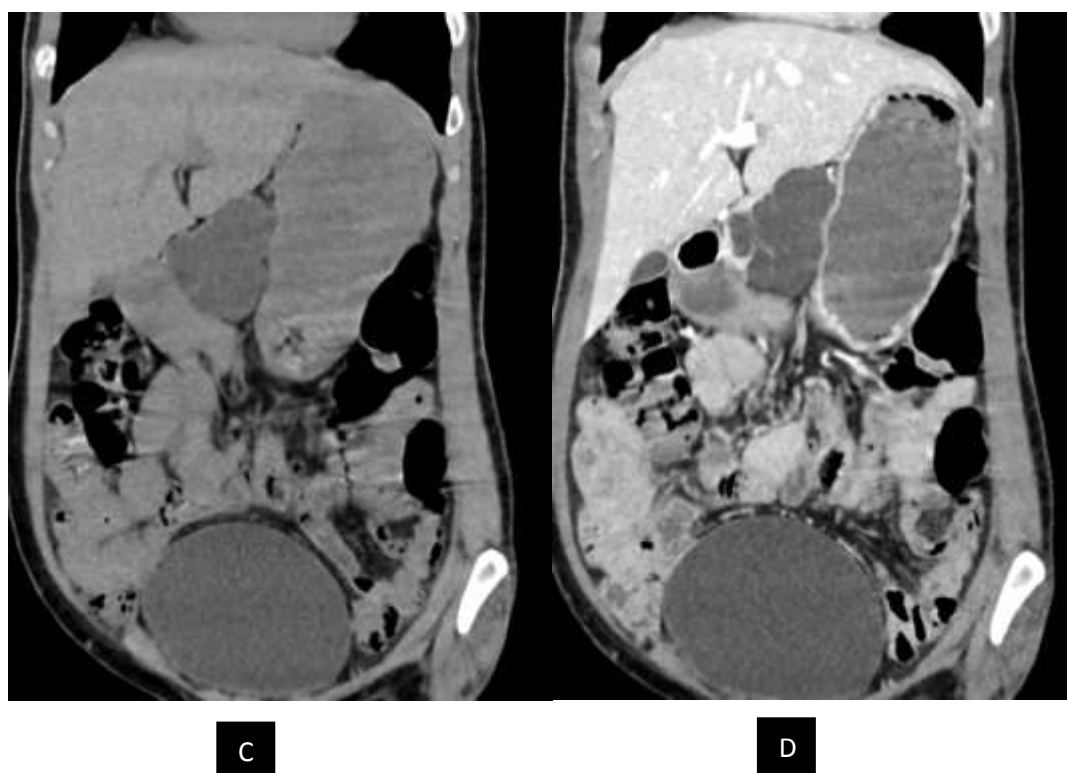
A-axial unenhanced, B-axial enhanced, C - coronal unenhanced and D- coronal enhanced CT images in 29years old male showing fairly well defined intensely enhancing soft tissue density lesion in head and uncinate process of pancreas. HPE- malignant neoplastic lesion, neuroendocrine tumor.
